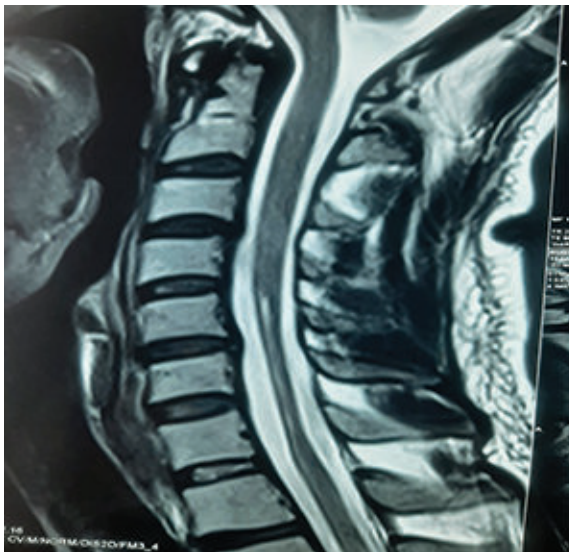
Cervical spine MRI showing segmental narrowing of the cord at C5 to C7 levels with intramedullary signal changes (both neutral and flexion view).
